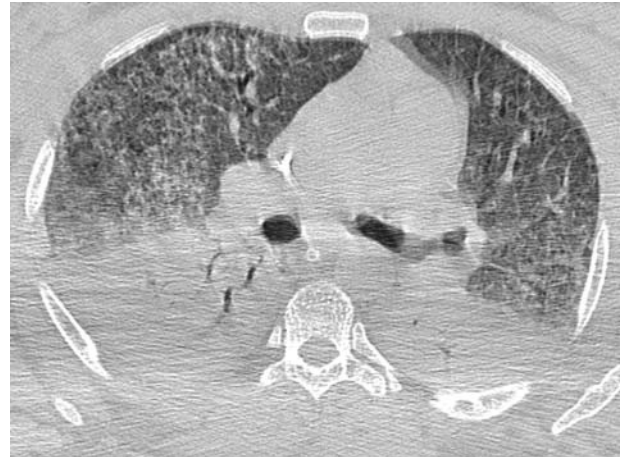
A 31-year-old man with leptospirosis. Computed tomography shows bilateral airspace nodules and airspace consolidation involving mainly the subpleural regions.
